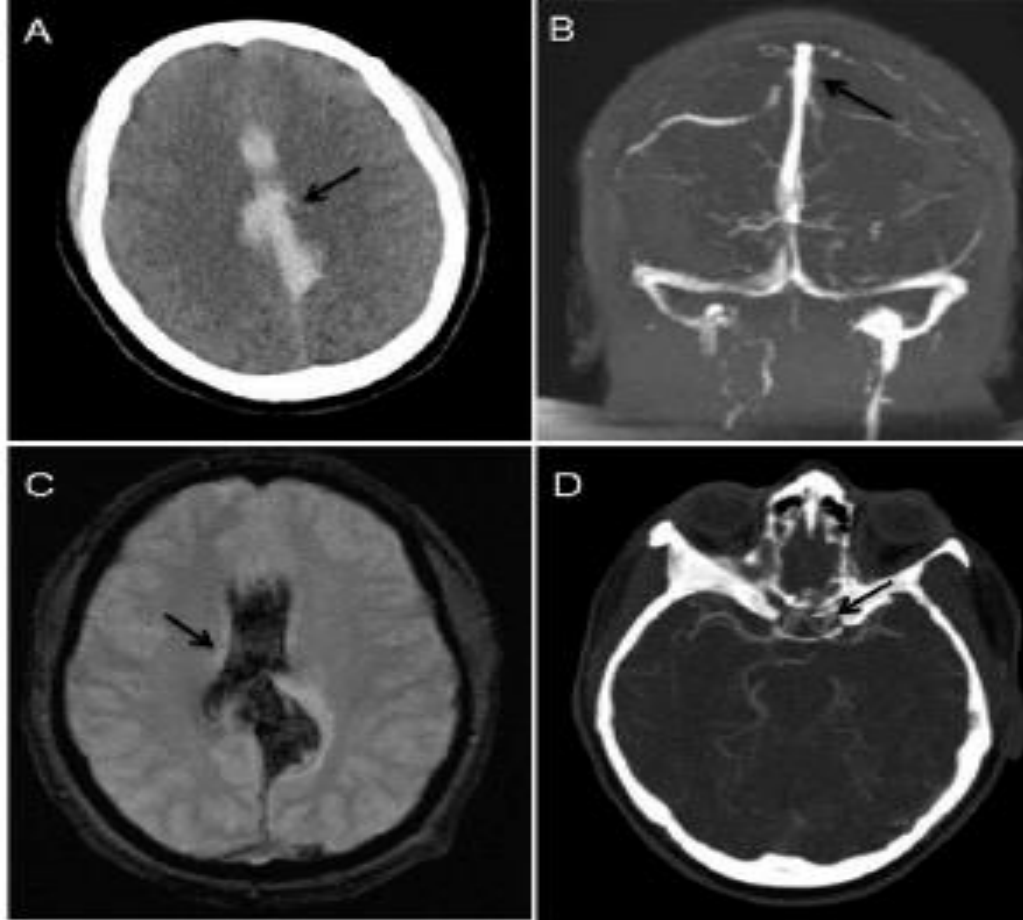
A) Non-contrast head CT revealing extensive interhemispheric and subarachnoid haemorrhage (arrow). (B) MRV of the Head demonstrating patency of the sagittal sinus in the region of the haemorrhage (arrow) and absence of dural sinus thromboses. (C) MRI brain, hemoflash sequence, corroborating the area of haemorrhage (arrow). (D) CT angiogram of head demonstrating a small, incidental left supraclinoid internal carotid artery aneurysm (arrow). No obvious vasculitic changes or abnormalities in the areas of intracranial haemorrhage seen.
